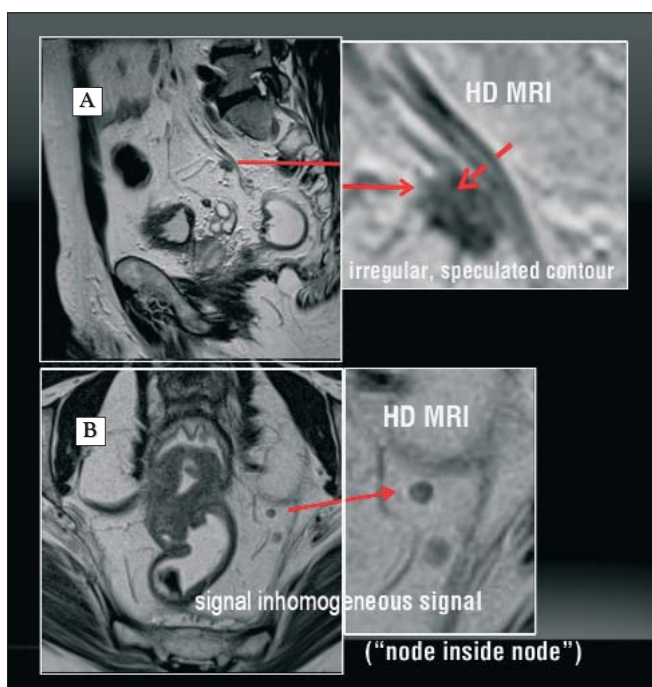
Additional morphological criteria for the evaluation of lymphatic infiltration using MRI. If lymph nodes have (A) an unclear and spiculated margin or (B) a heterogeneous appearance (node inside a node), we can be sure that they have metastases
